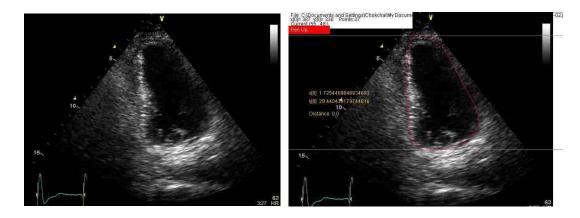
Show the left ventricle edge detection form echocardiogram
